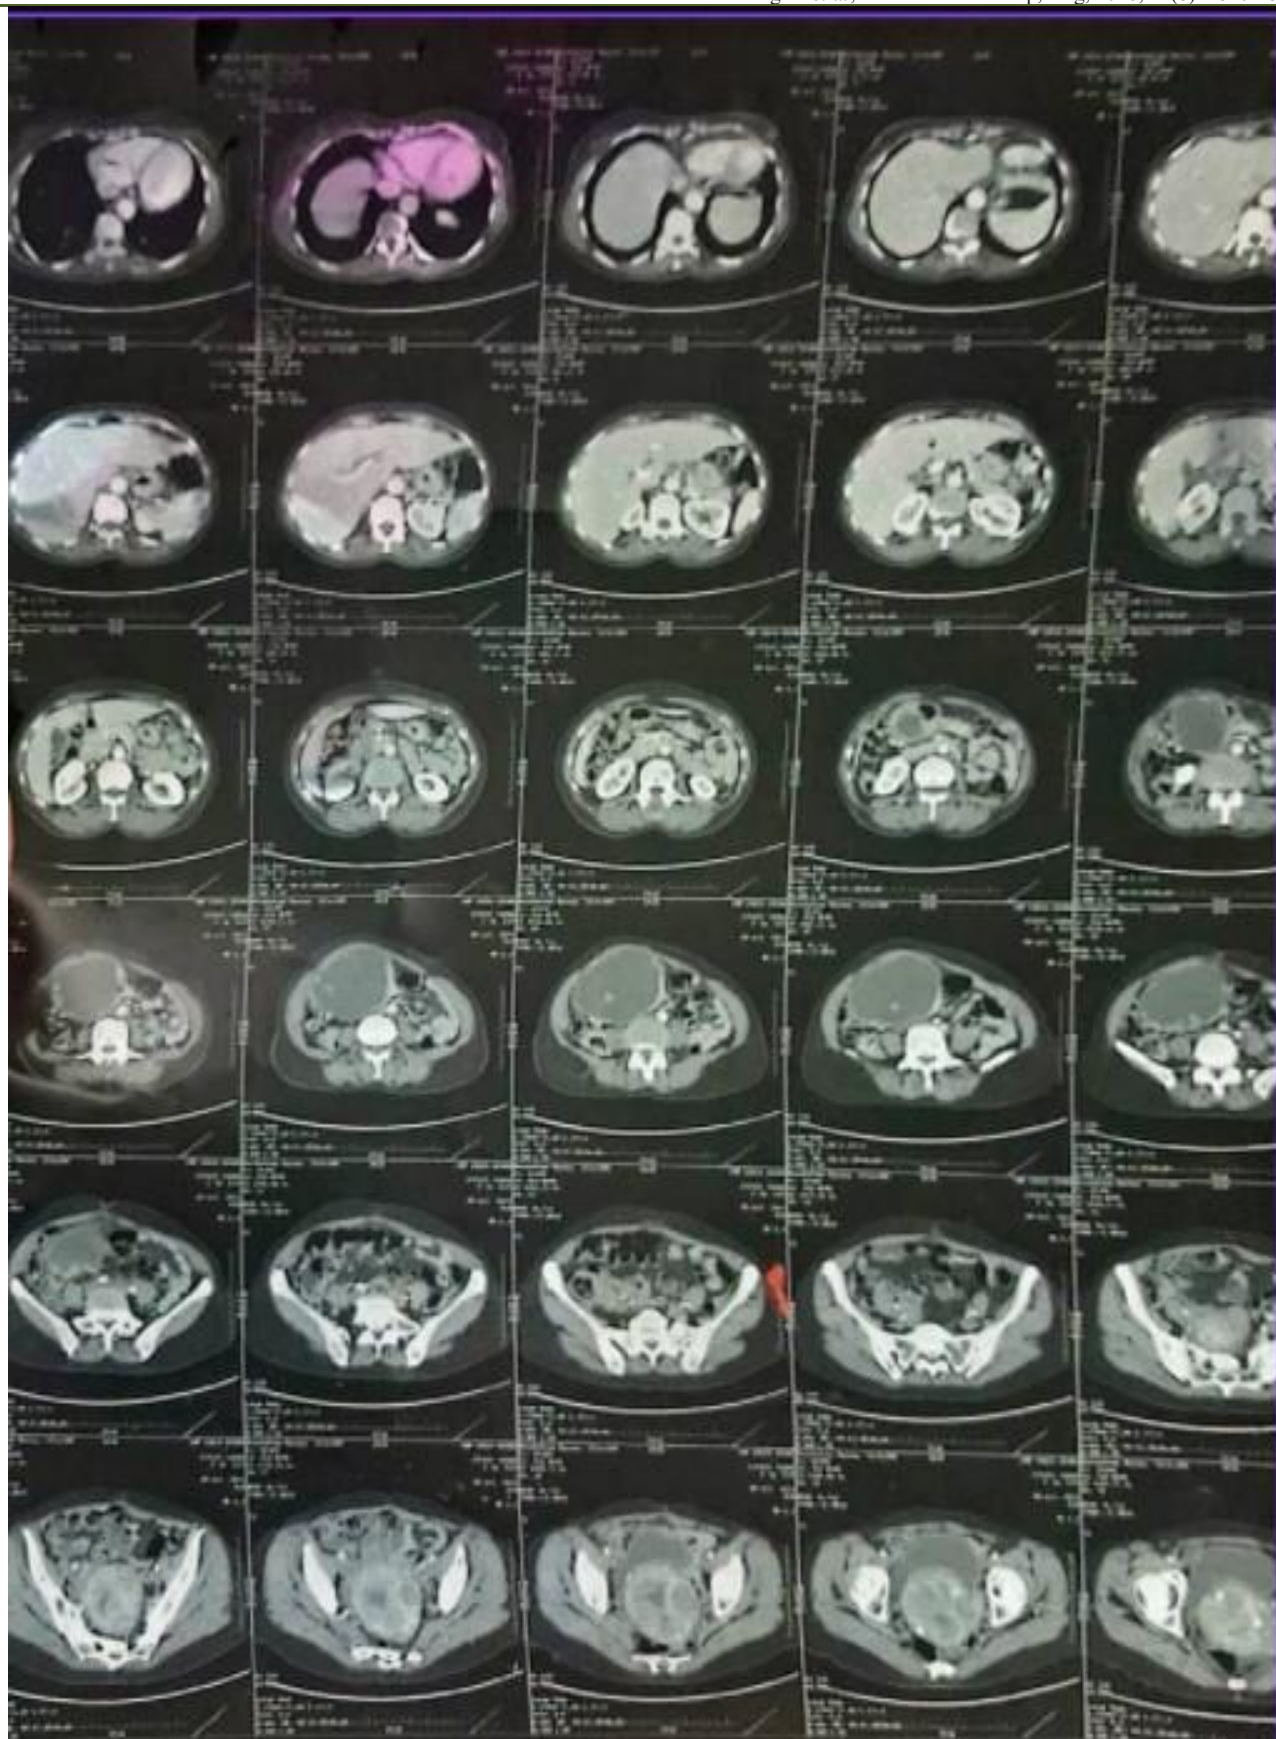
Contrast-enhanced abdominal CT scan demonstrating a predominantly cystic gastric antral mass with a large extraluminal component, initially suggestive of a gastrointestinal stromal tumor (GIST)
